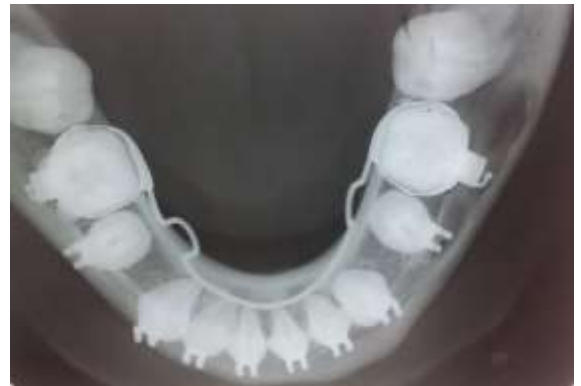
Shows occlusal radiograph
